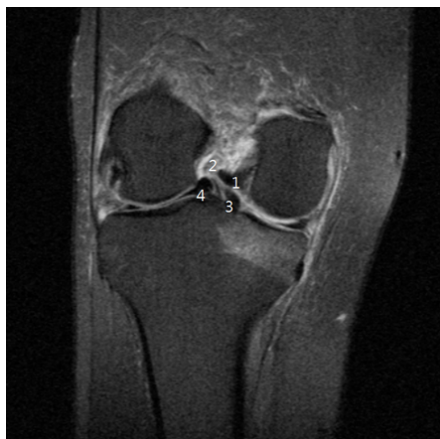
T2-weighted coronal MR image shows four structures in the intercondylar notch to produce the “quadruple cruciate sign”: (1) normal PCL; (2) increased signal ACL due to edematous change and partial tear; (3) displaced bucket-handle fragment from medial meniscal tear; (4) displaced bucket-handle fragment from lateral meniscal tear. Bone contusion in the medial tibial plateau is also noted.
